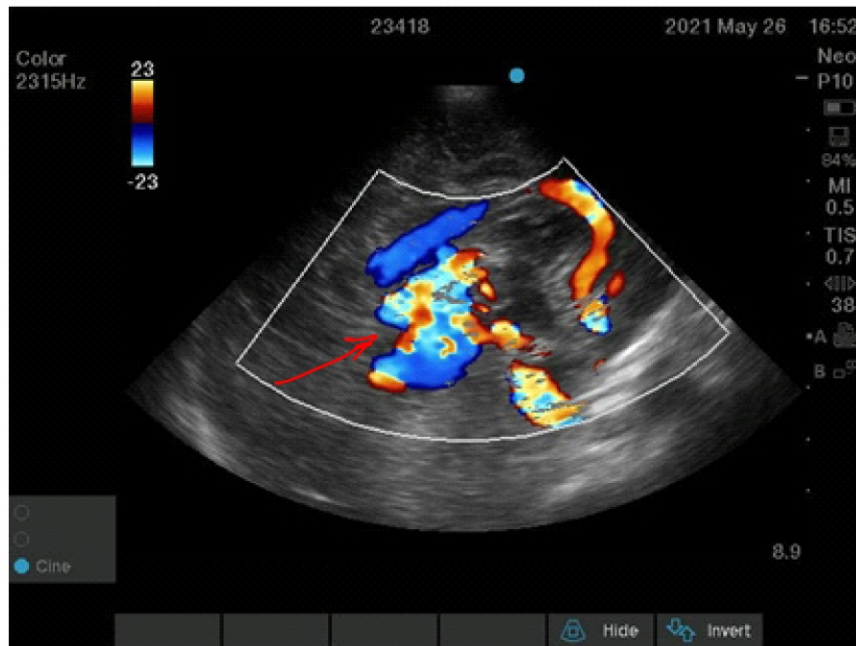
Postnatal Ultrasound doppler showing vein of Galen aneurysmal malformation (arrow)
